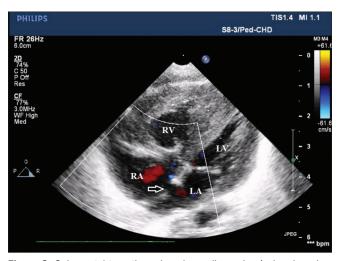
Subcoastal transthoracic echocardiography 4-chamber view showing the absence of thrombus in the right atrium and atrial septal defect post-BAS (white arrow). BAS: Balloon atrial septostomy
